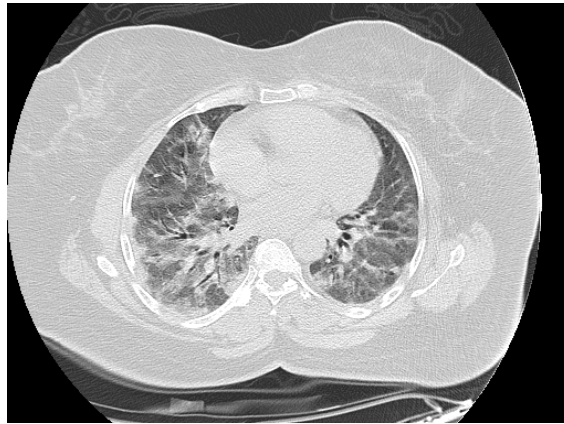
Axial computed tomography (CT) scan lung window for a 55 years old female patient demonstrated extensive diffuse bilateral ground glass opacities, the patient is treated for pulmonary edema and the CT finding is resolved.
